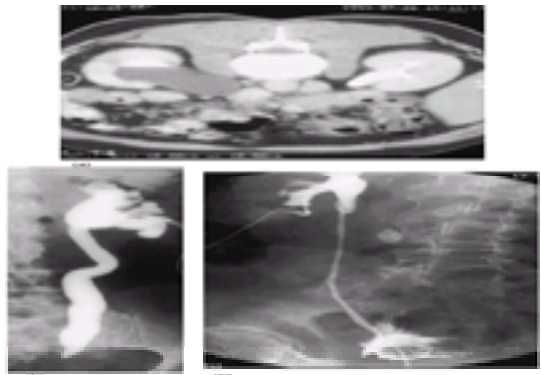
(a) Computed tomogram demonstrating right-sided hydronephrosis; (b) antegrade pyelogram following percutaneous nephrostomy in a patient with malignant obstruction to the distal ureter, demonstrating hydronephrosis and dilatation of the distal ureter; (c) a double-J stent relieving malignant obstruction after percutaneous nephrostomy and antegrade placement; [(a) and (c) by courtesy of Dr Nigel Cowan FRCR].
